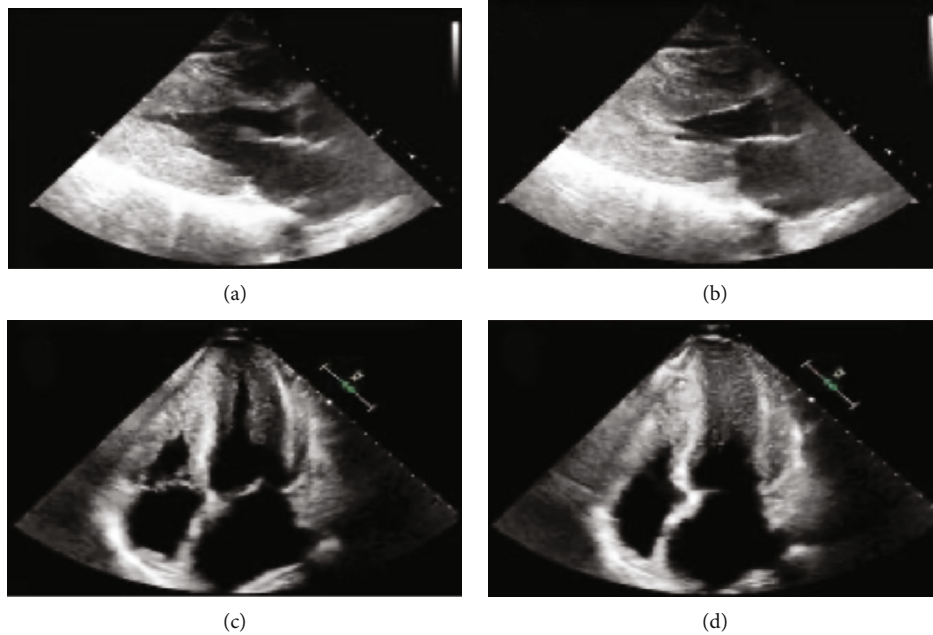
2D echocardiography parasternal long-axis view in diastole (a) and systole (b) along with apical 4-chamber view in diastole (c) and systole (d) showing apical hypertrophy in both left and right ventricles (first attachment).
